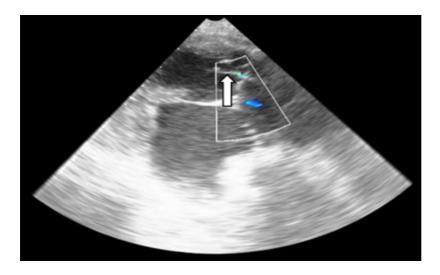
Transoesophageal echocardiogram on admission demonstrated severe Carpentier IIIB mitral regurgitation from chordal entrapment by the pacing wire (arrow), without pericardial effusion.
